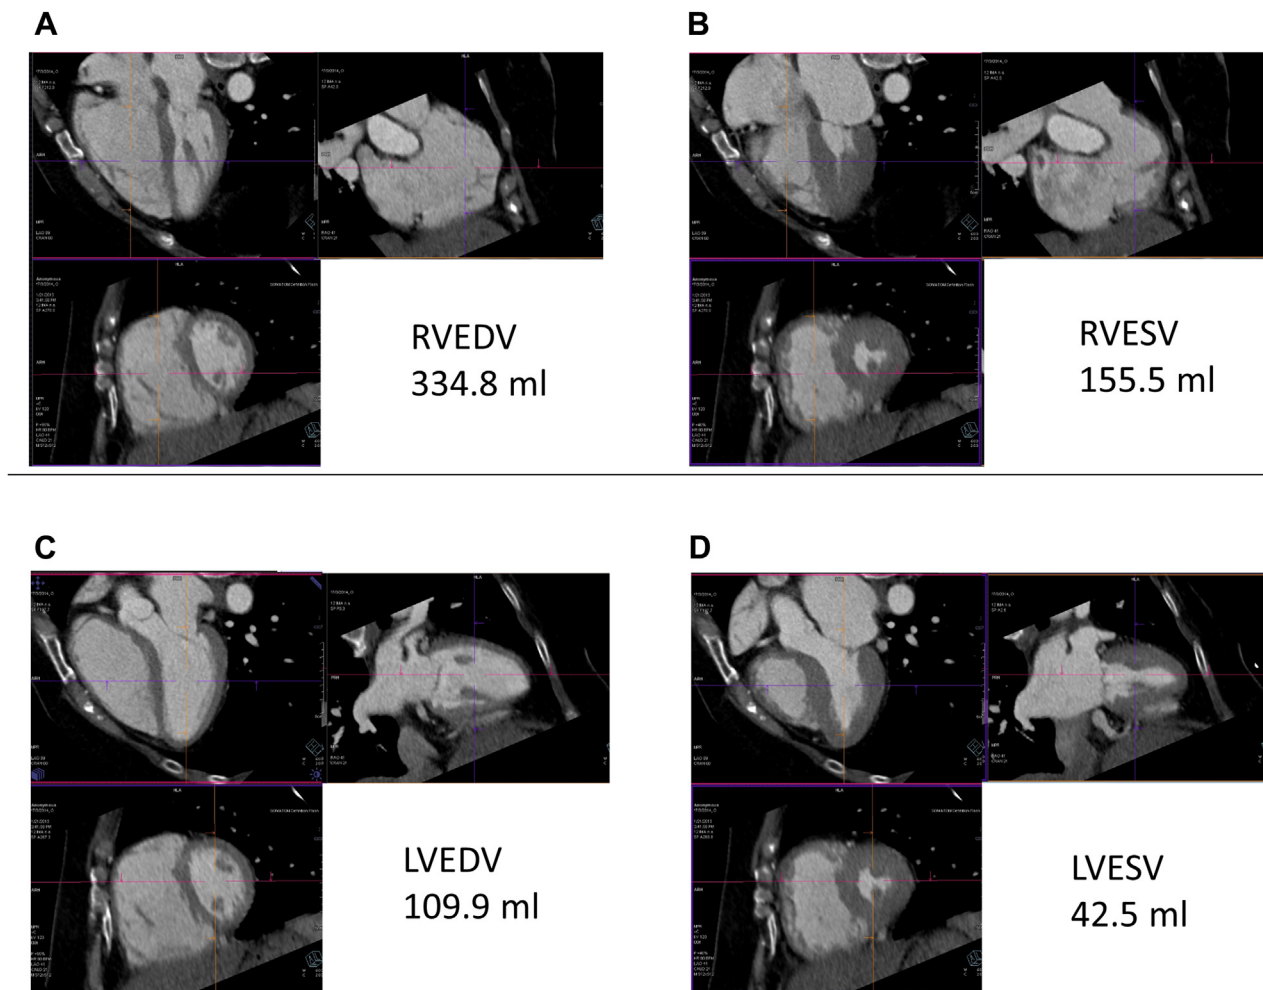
A representative example of right and left ventricular volumes. In each panel, the left superior image is shown as a transverse CT image. The left inferior images are shown along the short axis and the right superior images are shown along the long axis. (A) Right ventricular (RV) volume analysis in the diastolic phase. (B) RV volume analysis in the systolic phase. (C) Left-ventricular volume analysis in the diastolic phase. (D) Left-ventricular volume analysis in the systolic phase. This case shows 334.8 mL as the end-diastolic volume of RV and 155.5 mL as the end-systolic volume of RV, and the Q_p values are calculated as $179.3 \text{ mL} \times \text{heart rate beats/min}$. In the same way, this case shows 109.9 mL as the end-diastolic volume of LV and 42.5 mL as the end-systolic volume of LV, and the Q_s values are calculated as $67.4 \text{ mL} \times \text{heart rate beats/min}$. Finally the Q_p/Q_s ratio could be calculated as $2.66 (179.3 \text{ mL} \times \text{heart rate beats/min}/67.4 \text{ mL} \times \text{heart rate beats/min})$.
